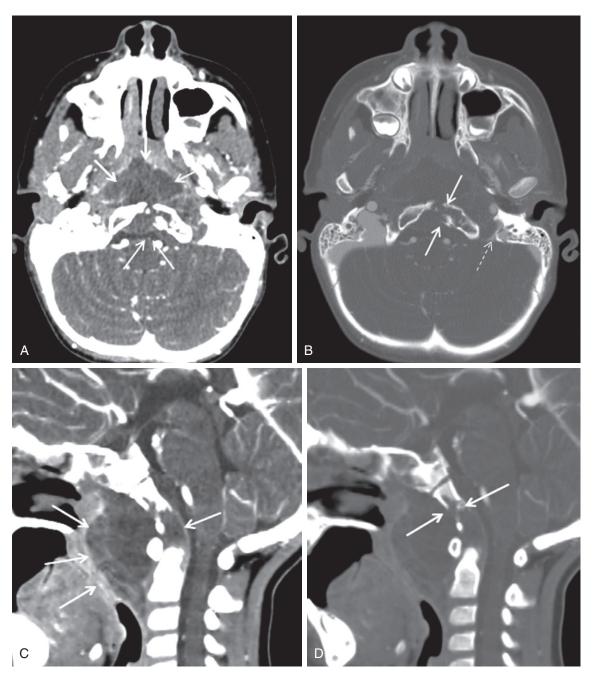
Patient presenting with nasal speech and cranial nerve deficits. A, Axial contrast-enhanced CT on the soft tissue window setting, at the level of the skull base, delineates a large soft tissue mass *(arrows)* centered at the clivus and both anterior and posterior to it (i.e., intracranial extension). B, Axial image on the bone window setting delineates associated bone erosion *(solid arrows)* and invasion of the left jugular foramen *(dashed arrow)*. C, Sagittal soft tissue reconstruction delineates extent of the mass both into the naso- and oropharynx as well as its intracranial extension *(arrows)*. D, Sagittal reconstruction on the bone window setting delineates the extent of clival erosion *(arrows)*.
